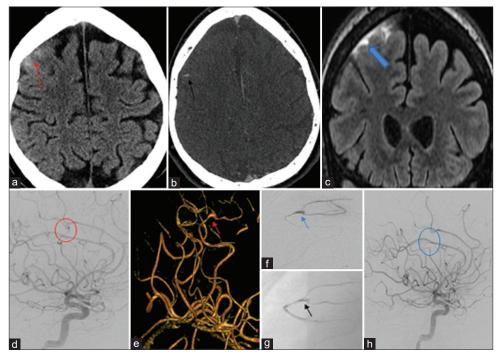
A 36-year-old male admitted for aortic root abscess treatment and developed slurred speech. Noncontrast brain CT (a) demonstrated trace of subarachnoid hemorrhage over the right frontal convexity (red arrow), CTA (b) demonstrated tiny outpouching (black arrow) in a distal branch of the right middle cerebral artery in the region of the subarachnoid hemorrhage. Coronal FLAIR sequence MRI (c) confirmed the subarachnoid hemorrhage (blue arrow). Cerebral angiogram (DSA) right ICA injection lateral view (d) showed an irregular 2 mm aneurysm (red circle) in the distal branch of the superior division of the right middle cerebral artery. The small aneurysm was better seen on 3D image (e) (red arrow) and on the microcatheter injection (blue arrow) (f) Pre-embolization and postembolization (g) image with the onyx cast filling the aneurysm (black arrow) and the supplying arterial pedicle. Follow-up 6 months postembolization right ICA injection lateral view (h) demonstrated complete occlusion of the aneurysm (blue circle) with maintained patency of the MCA.
